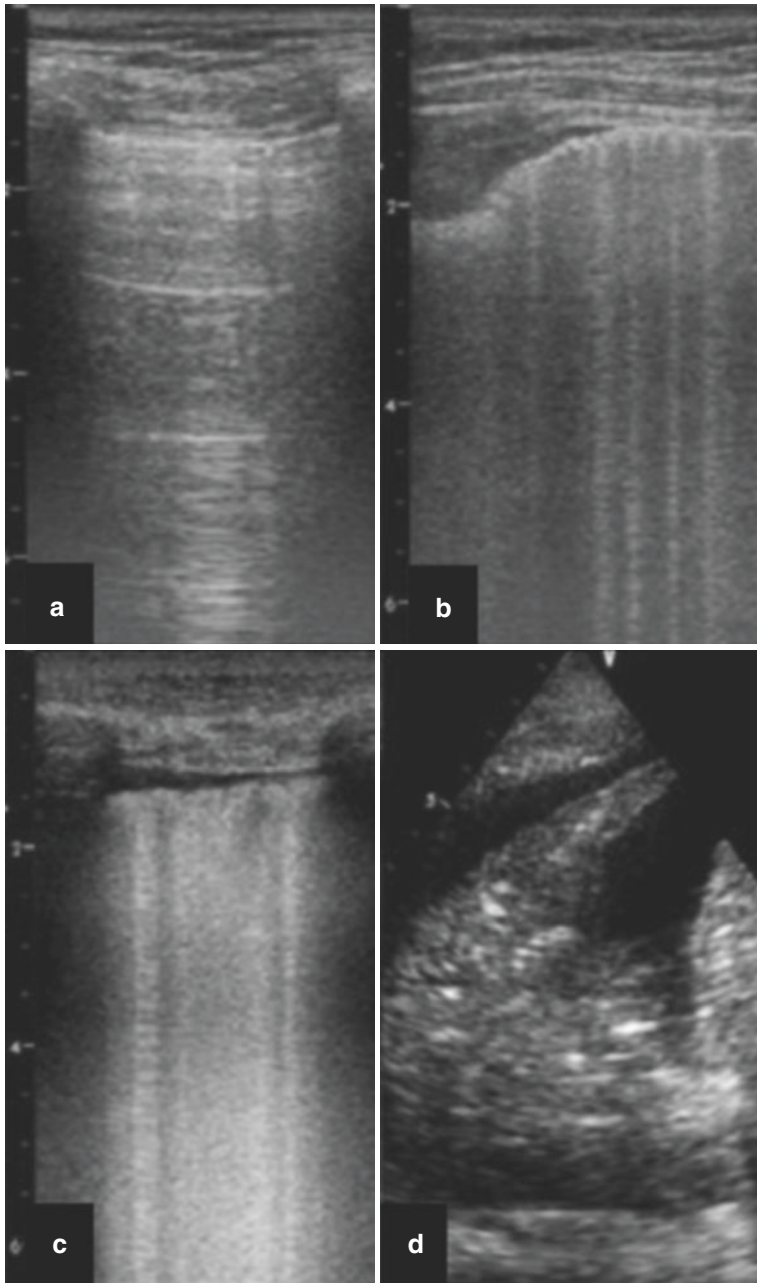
Lung ultrasonographic patterns. Panel (a) = normally aerated lung with pleural sliding (0 point). Panel (b) = B-lines separated by at least 5 mm (1 point). Panel (c) = B-lines separated by less than 5 mm (2 points). Panel (d) = consolidated lung, hyperechoic areas, and bronchograms (3 points)
